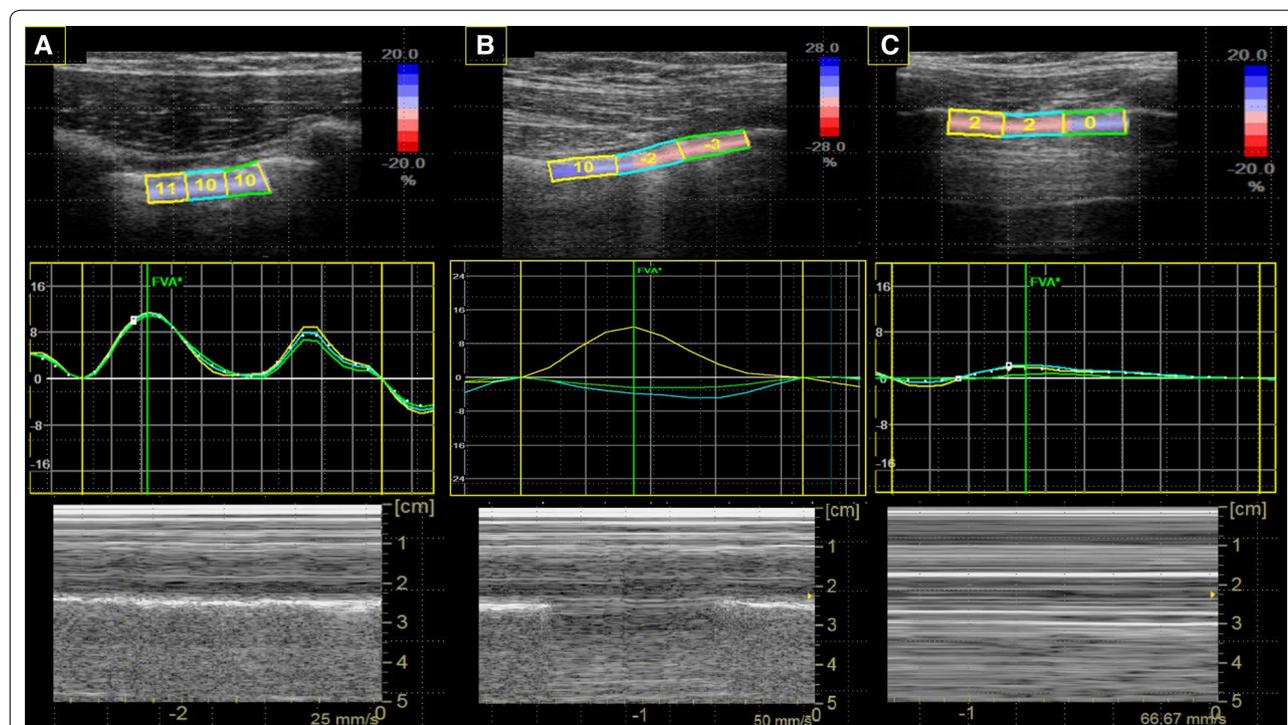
The figure presents speckle tracking of the segmental longitudinal strain and M-mode lung ultrasonography from the contralateral (normal) (a) and left (blunted) lung with a lung-point (b) and a pneumothorax view (c). The upper side of the picture shows the maximal longitudinal strain value of three segments (yellow, blue and green). The middle side of the picture shows longitudinal strain variations during the respiratory cycle of each segment symbolized with a curve of the corresponding color (yellow, blue or green). The low side of the picture shows M-mode evaluation of pleural sliding on the same lung ultrasound view. Normal lung evaluation (longitudinal scan) a shows maximal longitudinal strain segmental values of approximately ten symmetric segmental curves after the respiratory cycle and a classic lung sliding or “seashore sign” picture in M-mode. Lung point view (transversal scan) b shows a normal longitudinal strain value of the yellow segment (sliding lung) and low values of the blue and green segment (the pneumothorax part of the view) with their respective curves. M-mode shows the sequence of a typical “stratosphere sign” (abolition of lung sliding) with a normal lung-sliding image (“seashore sign”). Pneumothorax view (longitudinal scan) c shows an altered longitudinal strain value for all segments with associated curves showing no variation during the respiratory cycle. M-mode shows an absence of lung sliding (“stratosphere sign”)
